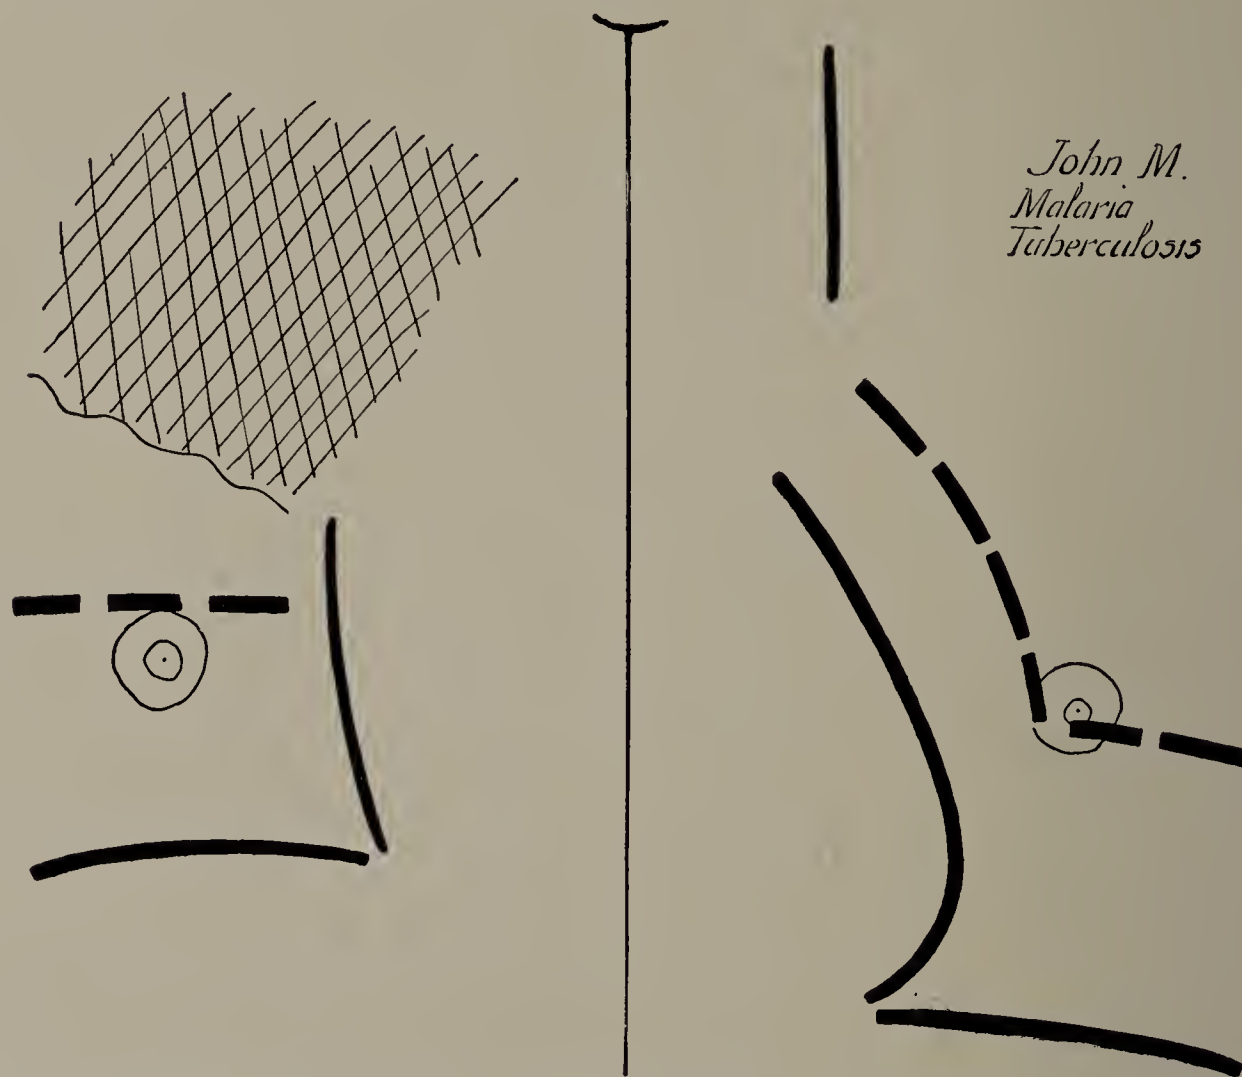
John M. X-ray tracing. (One-third life size.) Right apex darker than normal; excursion of diaphragm shorter and higher on right side.
